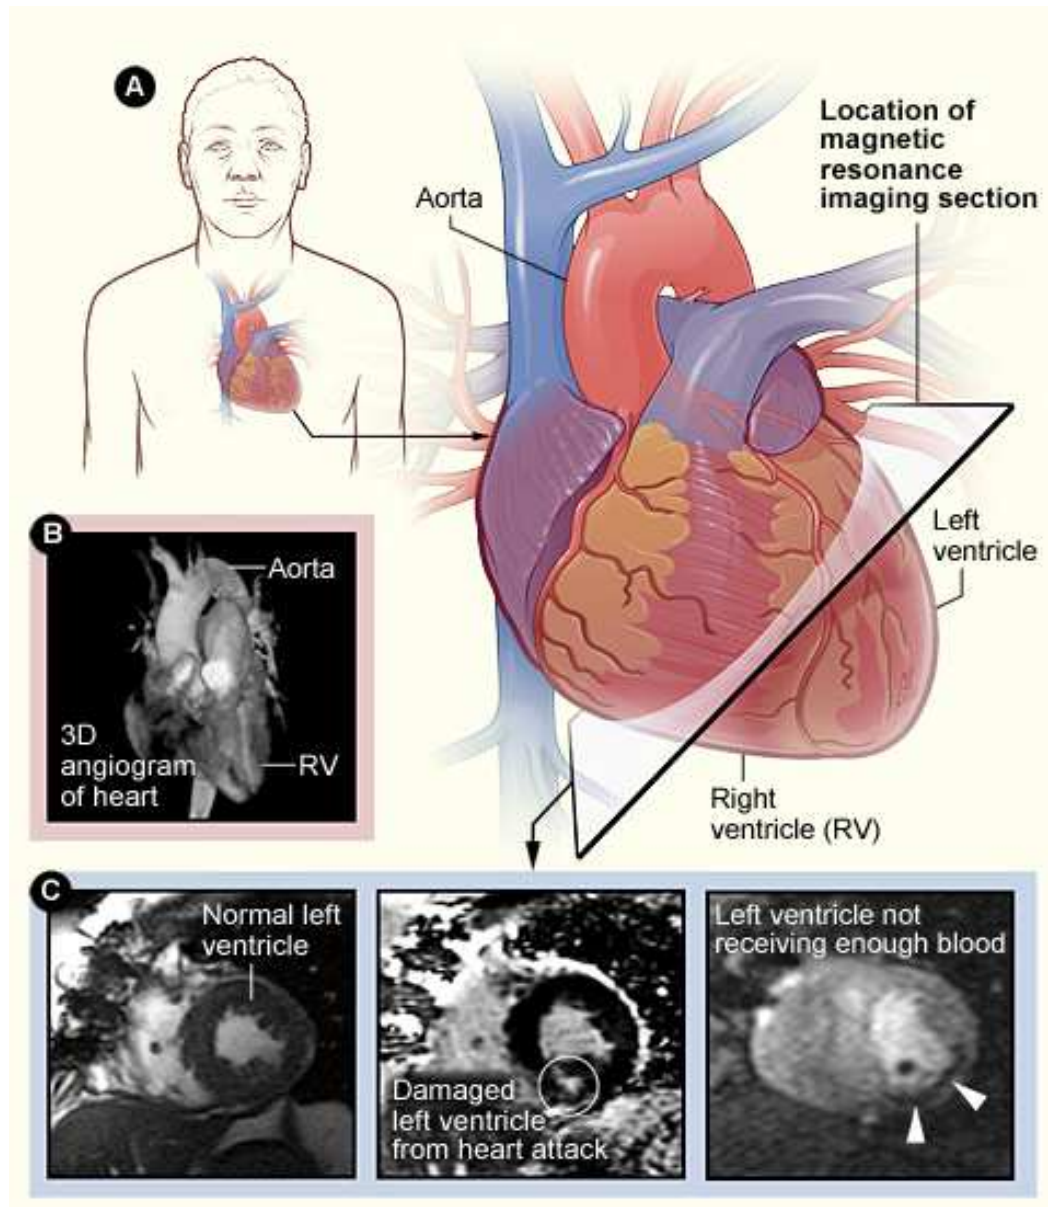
Cardiac MRI. Localisation of the heart in the body is shown in (A), with a given MR slice angle. An example of a 3D MR angiogram is shown in (B). (C) shows the left ventricle image acquired from the slice shown in (A) when healthy (left), damaged from heart attack (centre) and when the left ventricle is not receiving enough blood (right). Image obtained from www.daviddarling.info/encyclopedia/C/cardiacMRI.html
